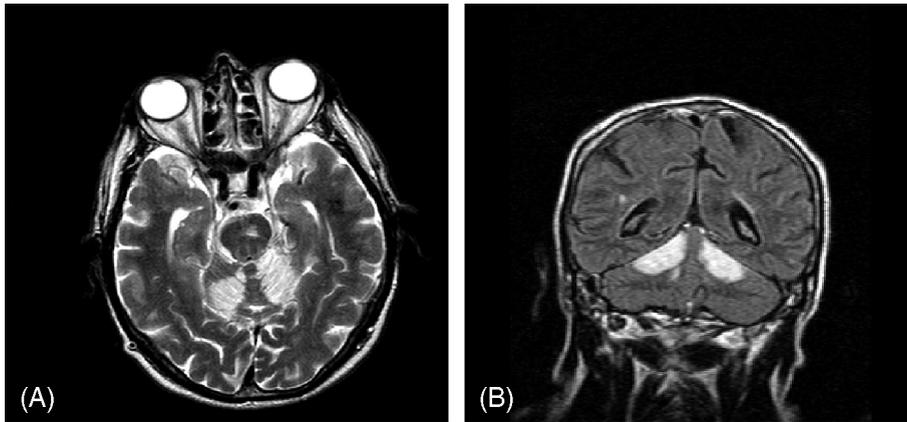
Bilateral infarcts involving both superior cerebellar artery territories shown by MRI axial (A) and coronal (B) slices.
